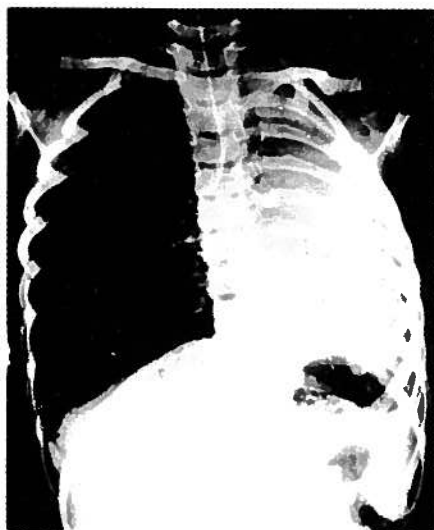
Roentgenogram of child who was referred for evaluation of chronic atelectasis of left lung. She had been involved in an automobile collision several months before referral. Bronchograms demonstrated a transected left main stem bronchus.
